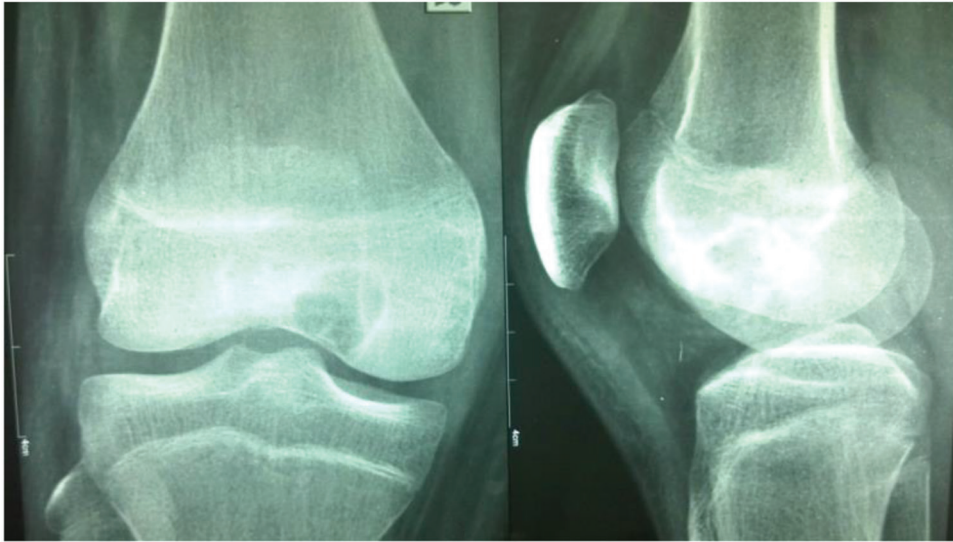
X-ray of the right knee showing a radiolucent expansile subchondral lytic lesion situated near the intercondylar region of the medial femoral condyle.
